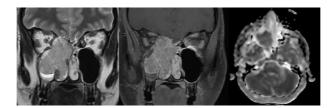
In coronal T2-weighted and post-contrast T1-weighted sections, invasion of the mass into the dura at the skull base and the extraconal space of the medial orbital wall is observed. In the axial ADC map, diffusion restriction (ADC value: 0.8×10^{-3}), supporting a highly cellular and high-grade tumor, is noted.
